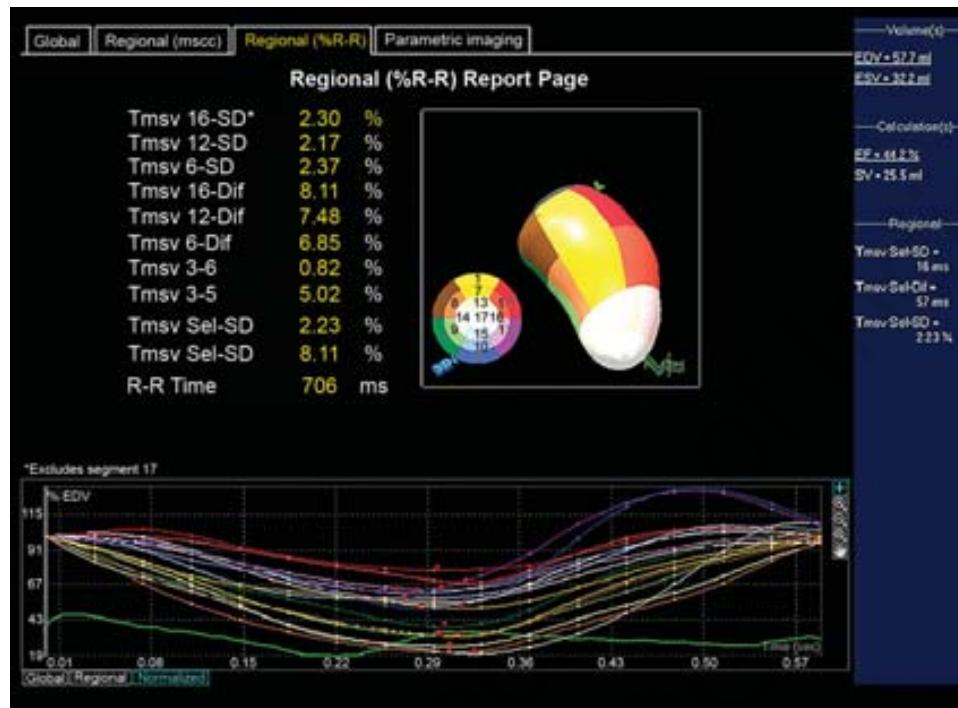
Left ventricular dyssynchrony analysis by three-dimensional echocardiography. Segmental volume waveforms are created to quantify regional mechanical dispersion.
